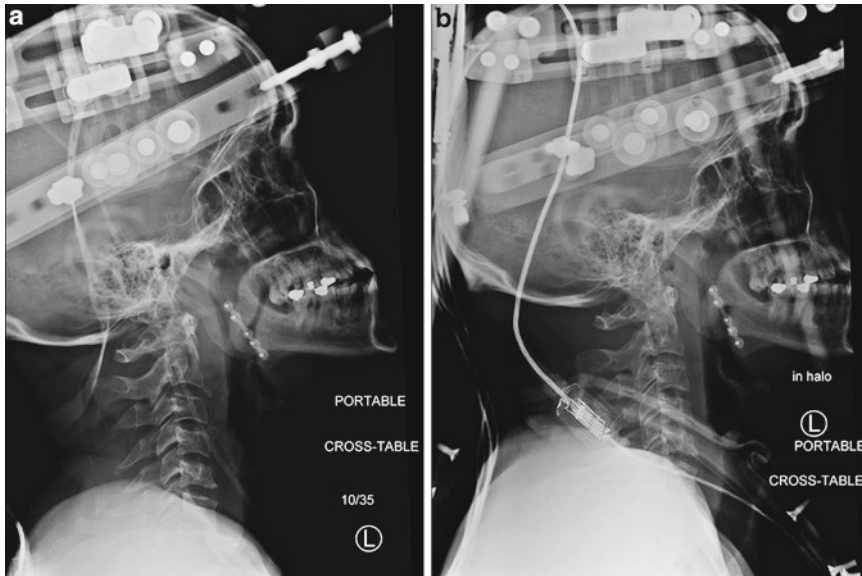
After gentle manipulation of the fracture, a significant reduction was achieved (a), and final upright radiographs in the halo orthosis demonstrated 2.7 mm of anterior translation (down from 7.5 mm)
